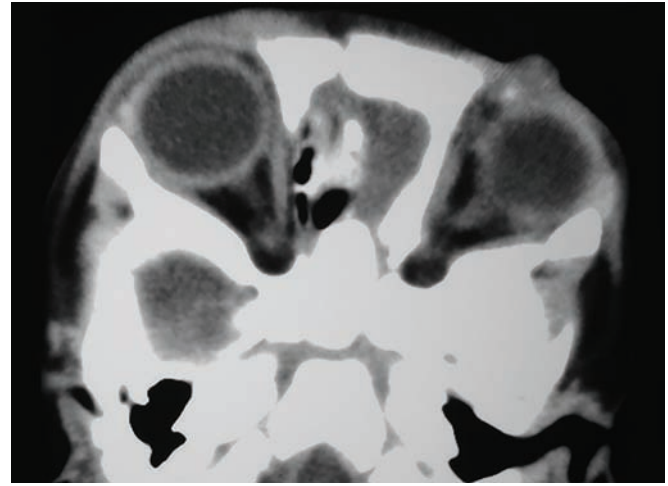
CT scan showing hyperdense heterogeneous orbital mass
